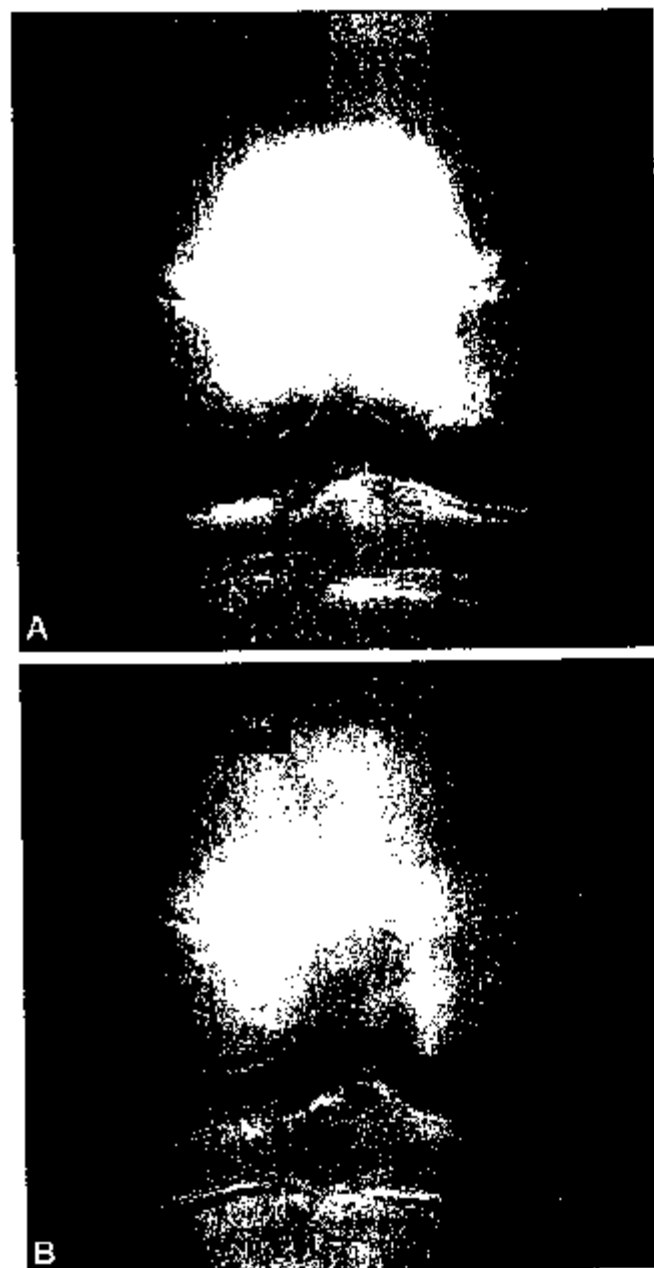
A, bilateral AP notch view radiograph in a 13-year-old boy with osteochondritis dissecans of both medial femoral condyles (arrows). These lesions remained symptomatic despite 1 year of nonoperative management including activity restriction and 2 months of protected weightbearing with splinting. B, bilateral AP notch view radiograph 12 months after transarticular drilling of the left knee and 9 months after transarticular drilling of the right knee, demonstrating healing of both lesions (arrows).
